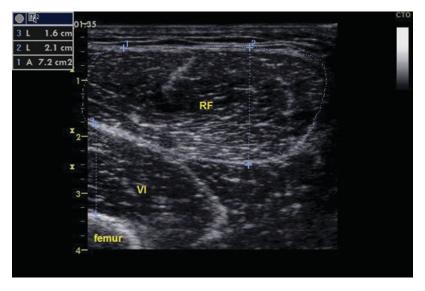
Image acquisition with a hand-carried ultrasound unit. The transducer is placed perpendicular (or longitudinal) to the skin without exerting compression, at the half distance between the anterior superior iliac spine (ASIS) and the upper pole of the patella (1) or at the border between the lower third and upper two-third between the ASIS and the upper pole of the patella (2)
